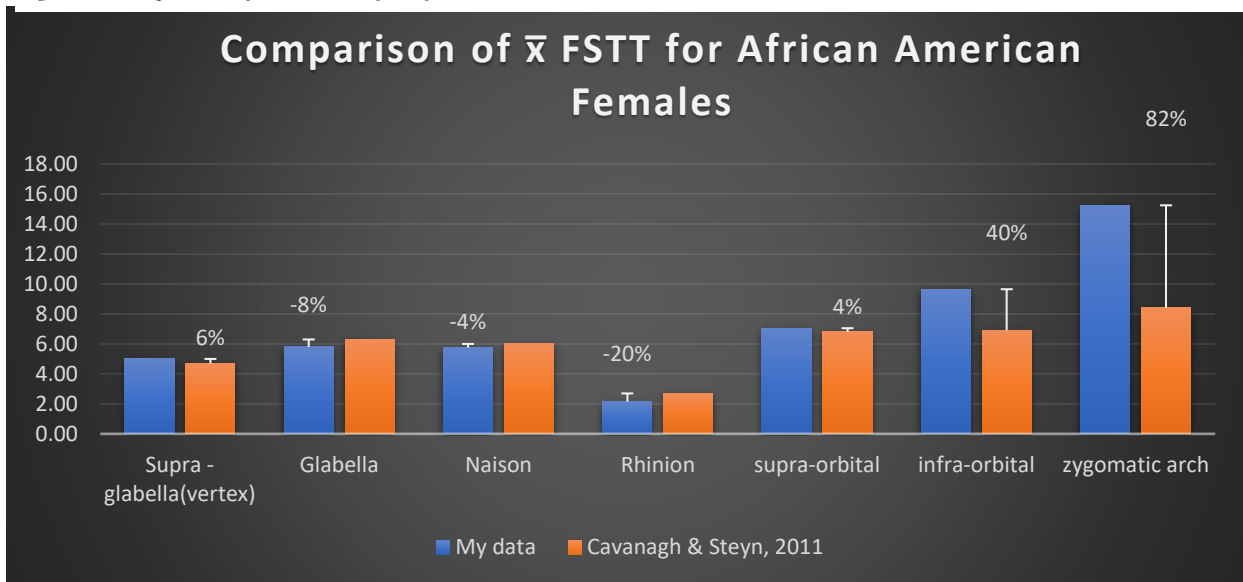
shows a graph and a table comparison of my data with a 2011 CT study of South African Black Females. (Cavanagh & Steyn, 2011) This study looked at FSTT values from the CT scans of 154 African females ages 18-35. They found low repeatability of the data between the two observers used, which could be due to landmark identification.
